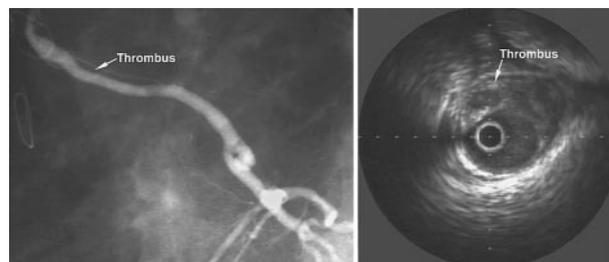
Angiographic and intravascular ultrasound appearances of laminated thrombus in recently implanted saphenous vein graft.
